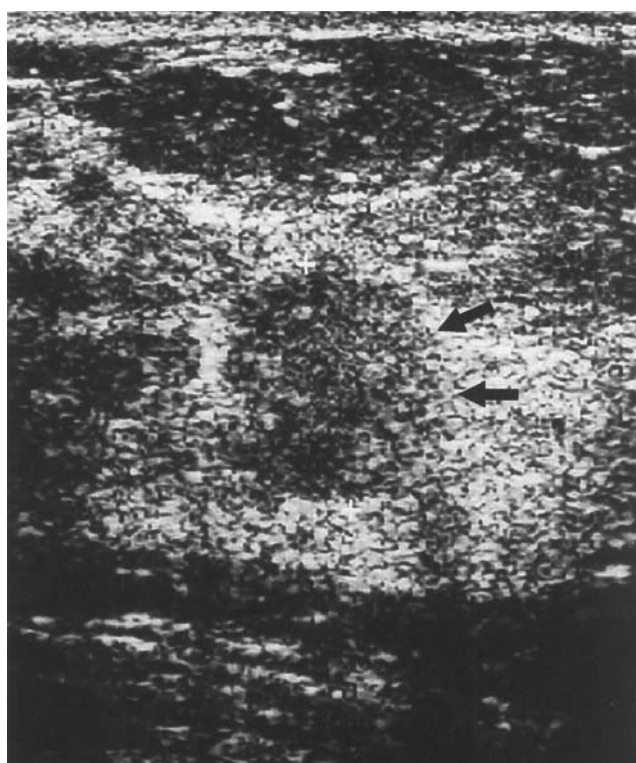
Ultrasonography showed a 1.5 cm nodule with well-defined margin and heterogenous echogenicity (arrows) in the medial part of the left breast.
